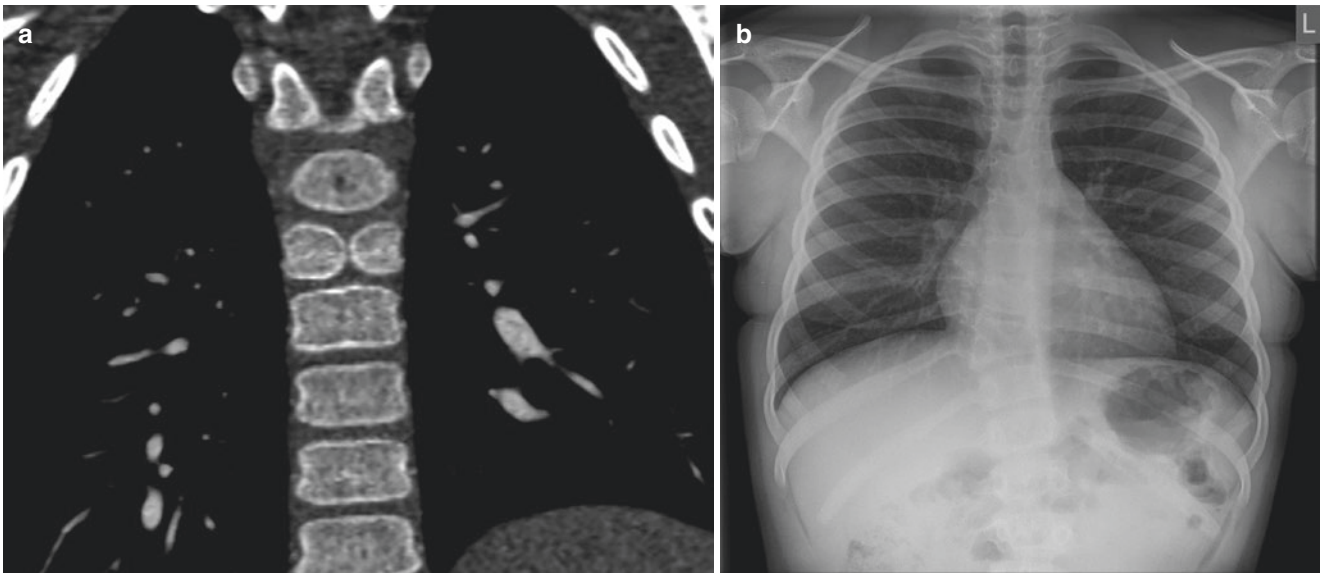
(a and b) CT Sagittal and coronal reconstruction of thorax reveals butterfly vertebrae of T6, typically seen in Alagille syndrome. These can also be seen on plain spinal xray
